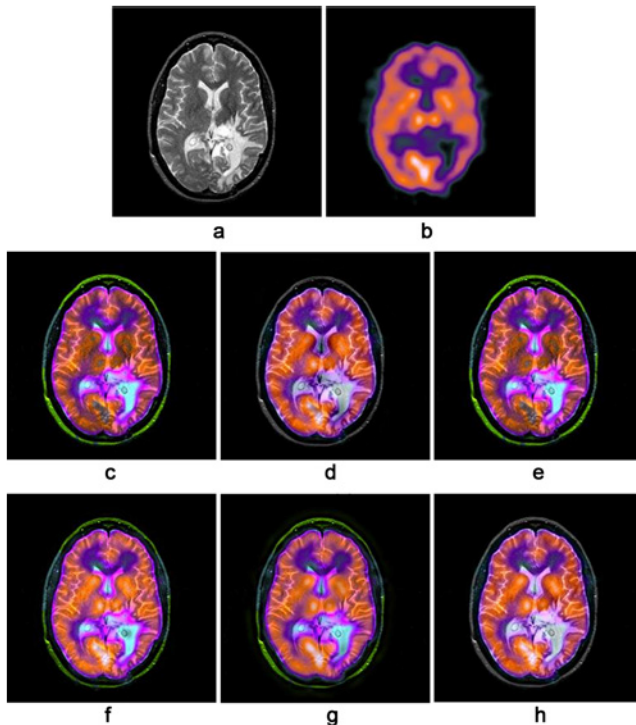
(a) MRI image, (b) SPECT image, fused image by (c) Method1, (d) Method2, (e) Method3, (f) Method4, (g) Method5, and (h) Method6.
